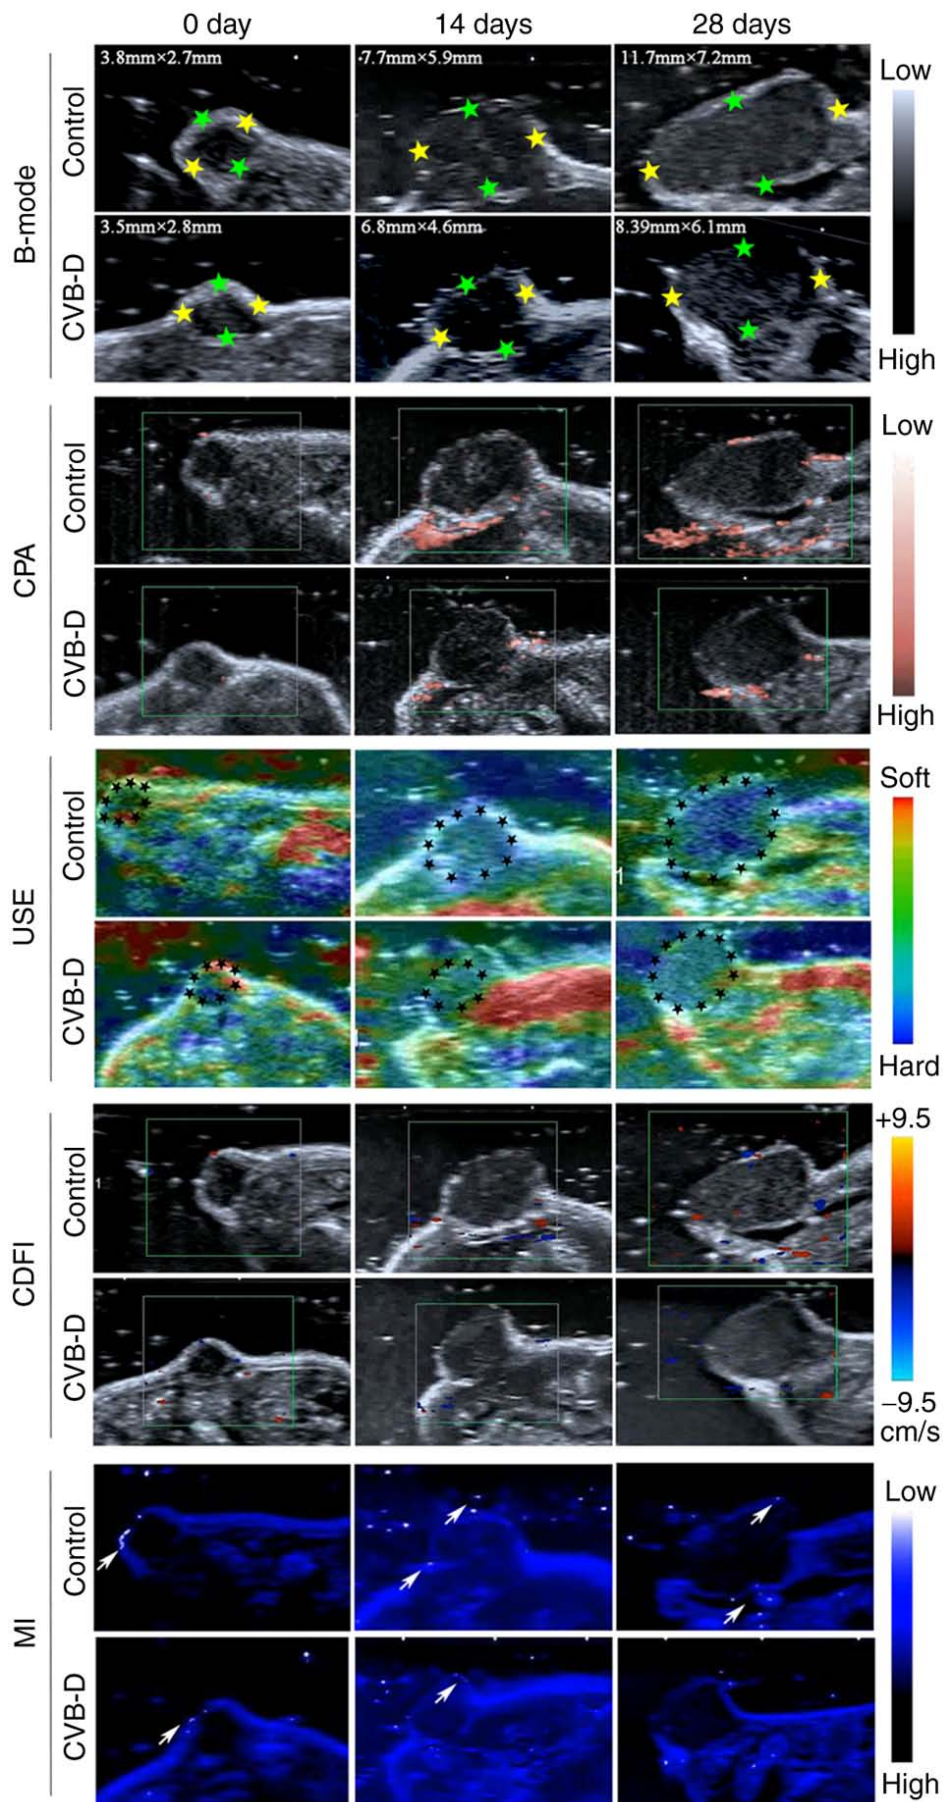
Ultrasonic imaging data of the non-small cell lung cancer xenograft tumors in the control and CVB-D treatment groups. This includes B-mode, CPA, USE, CDFI and MI. CVB-D, cyclovirobuxine D; B-mode, B-ultrasound; CPA, color power angiography; USE, ultrasonic elastosonography; CDFI, color Doppler flow imaging; MI, MicroPure Imaging.
